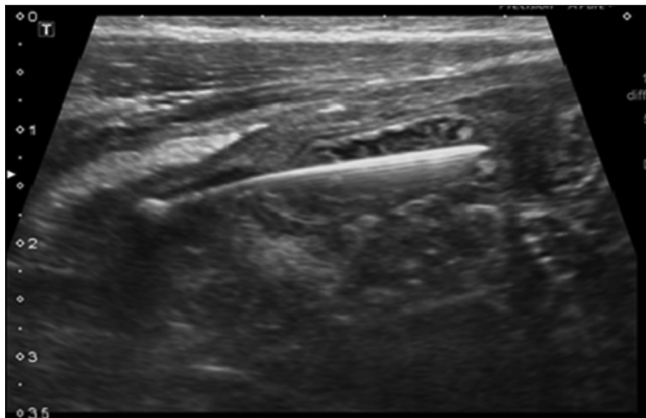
Sonographic imaging of right lower quadrant
